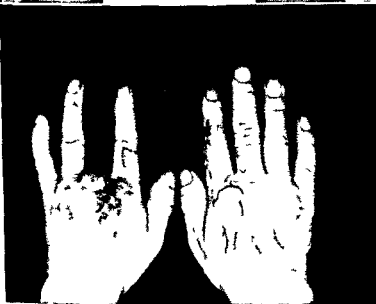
Acute radiation injury incurred by an employee who placed his hands under a 30 kv industrial x ray unit for 6 to 7 seconds approximately 14 times for a total of 84 seconds, estimated total roentgen dose in air 4 000 r (Upper left) Diffuse erythematous swelling 14 days after first exposure (Upper right) Complete destruction of skin in certain regions with atrophy of underlying tissue 1 month after exposure (Lower left) Status 10 months after exposure: middle finger of left hand has been amputated. Remainder of hands atrophic with stiffness due to underlying fibrosis. Free skin grafts have been used to cover the regions of destroyed skin (Lower right) Status 23 months after exposure: progressive atrophy, especially marked of the three digits of the left hand. Further radiation changes occurred necessitating additional surgical removal and skin grafting (Courtesy Drs Irving M. Aron, George T. Pack and Robert J. Boaher)
